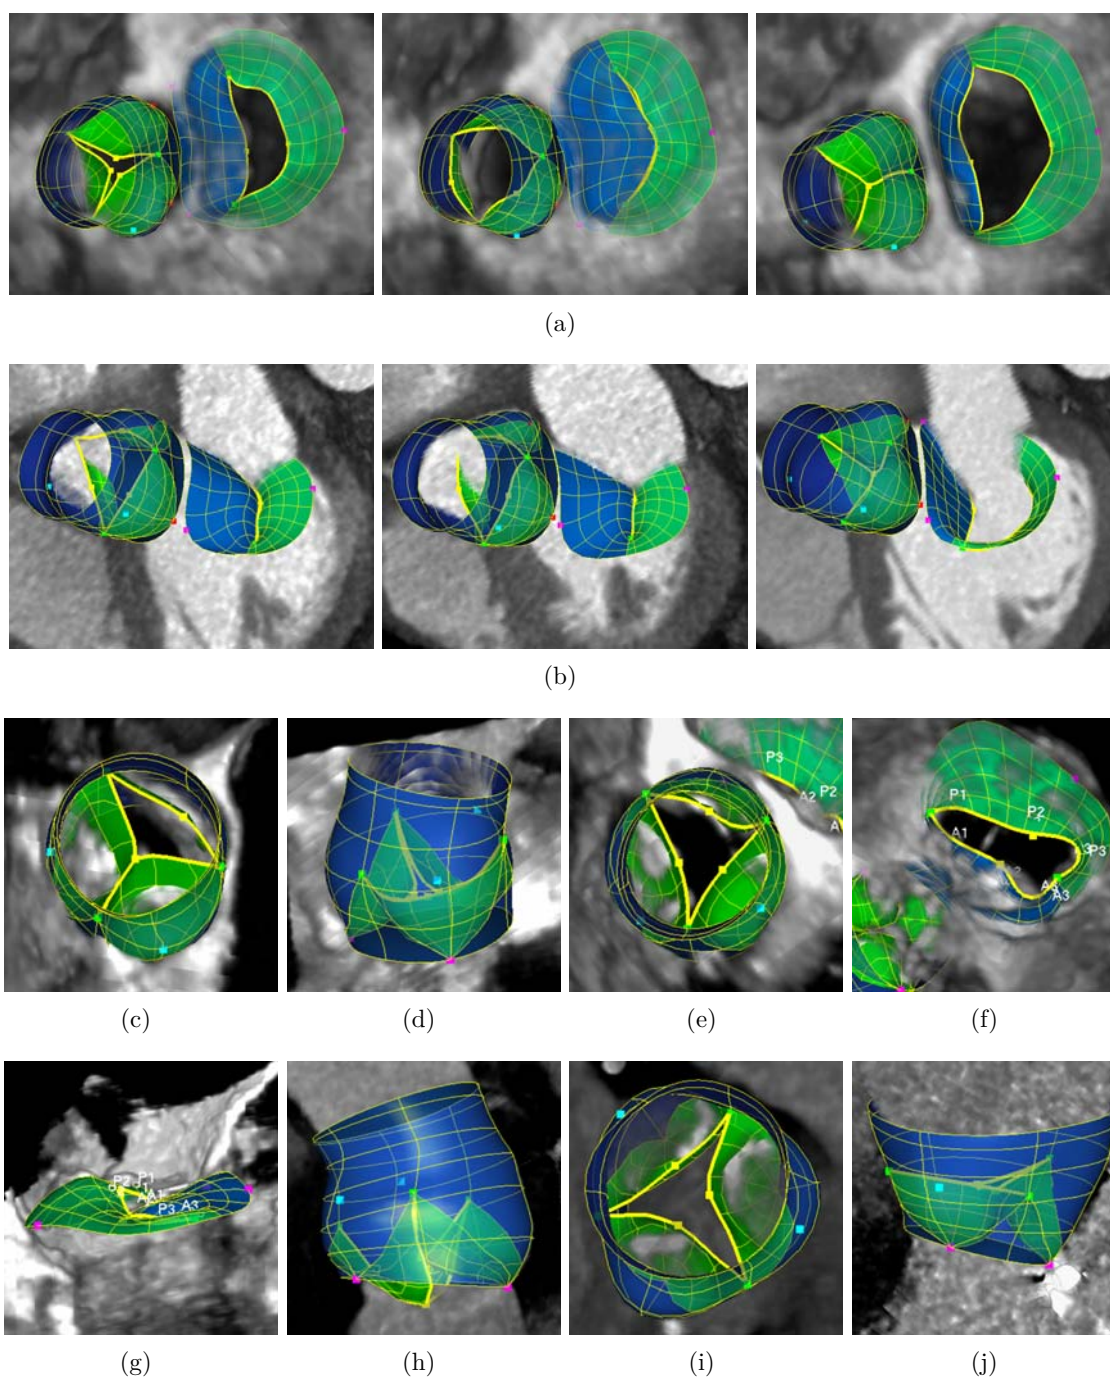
Examples of estimated patient-specific models from TEE and CT data: healthy valves from three different cardiac phases in (a) TEE from atrial aspect and (b) CT data in four chamber view. Pathologic valves with (c) bicuspid aortic valve, (d) aortic root dilation and regurgitation, (e) moderate aortic stenosis, (f) mitral stenosis, (g) mitral prolapse, (h) bicuspid aortic valve with prolapsing leaflets, (i) aortic stenosis with severe calcification and (j) dilated aortic root.
